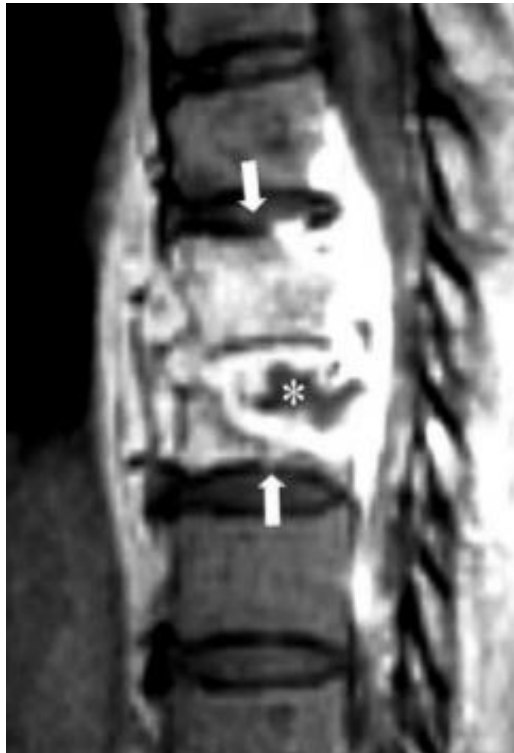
Sagittal T1+C MR image shows smooth enhancement of intraosseous abscess (asterisk).
